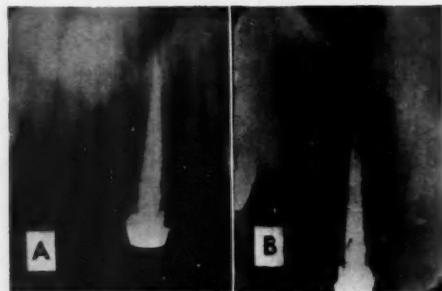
Failure of root resection due to leakage. *A*, Periapical involvement 11 months after filling of canal. *B*, Incomplete bone repair 1½ years following resection; note the leakage between the two gutta percha points "suspended" in the canal.
